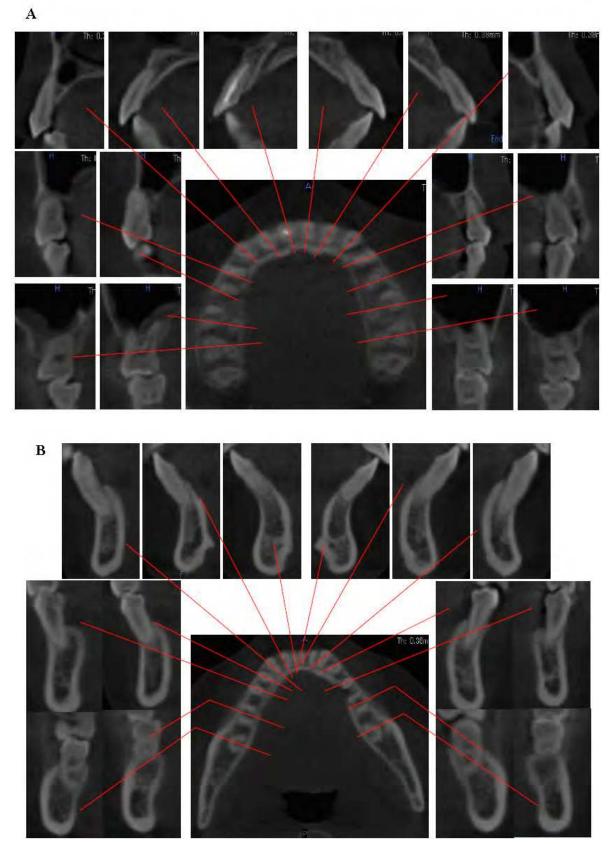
Cone-beam X-ray computed tomography (CBCT) images of the upper arch during retention phases (A) and CBCT images of the lower arch during retention phases (B).
